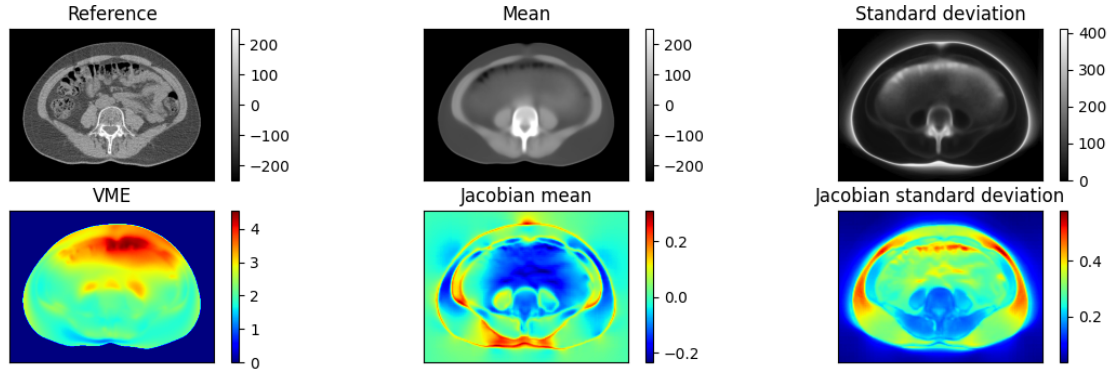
Resulting collage for the abdomen registration of 4603 CT scans. (Reference) shows the preprocessed reference image. (Mean) shows the mean intensity of all registered images. (Standard deviation) shows the intensity standard deviation of all registered images. (VME) visualise the mean VME for all registrations. (Jacobian mean) visualise the mean of the logarithm of the Jacobian in every point. (Jacobian standard deviation) show the standard deviation of the logarithm of the Jacobian in every point. For visibility purposes the intensity scale of the reference and mean images have been changed from -1024 HU to 1024 HU to -250 HU to 250 HU. VME = Vector magnitude error.
